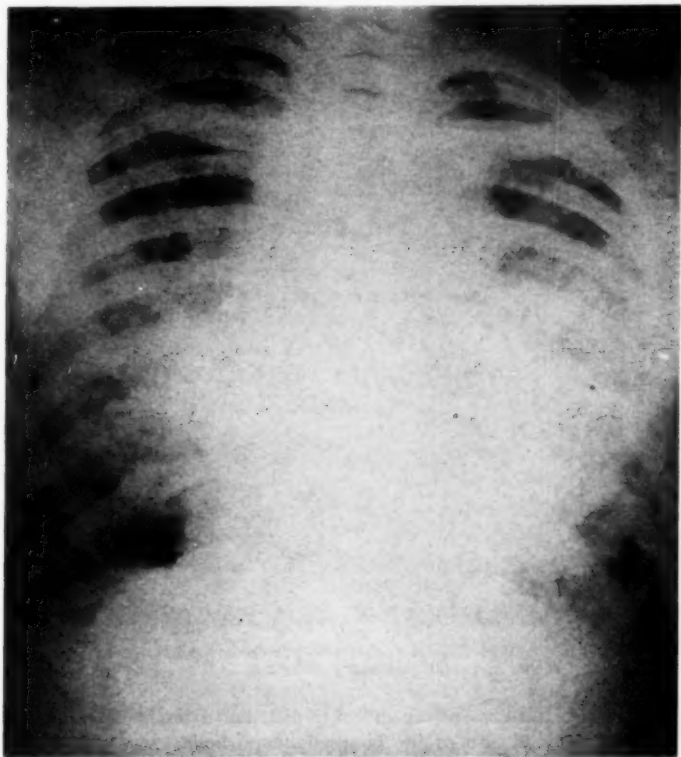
Roentgen-ray of chest taken in July 1936 revealing extensive infiltration of both lungs and enlarged hilar lymph nodes.
